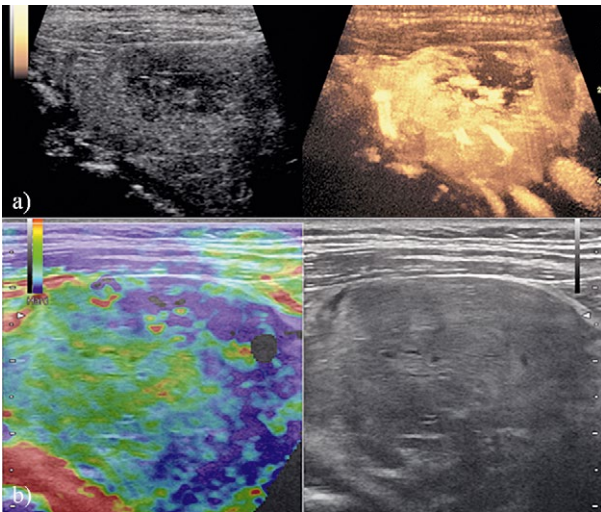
A 62 year old male patient with metachronic re-recurrence of thyroid metastases shown by contrast enhanced ultrasound with typical non enhancing areas (a) and heterogenous elastographic characteristics (b) corresponding to the typical finding of renal cell carcinoma.
